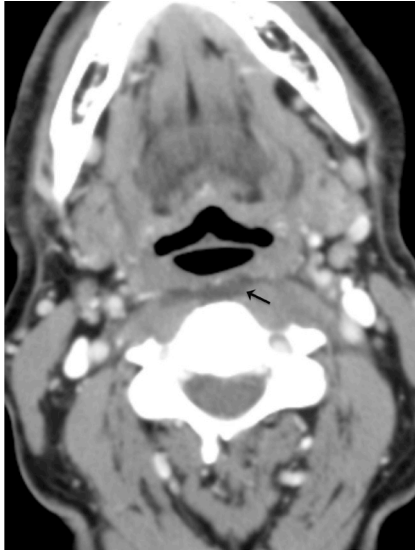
Contrast-enhanced axial CT image of the neck in soft tissue window depicts a laminar retropharyngeal effusion without enhancing walls (arrow). This is most probably reactive in nature.
